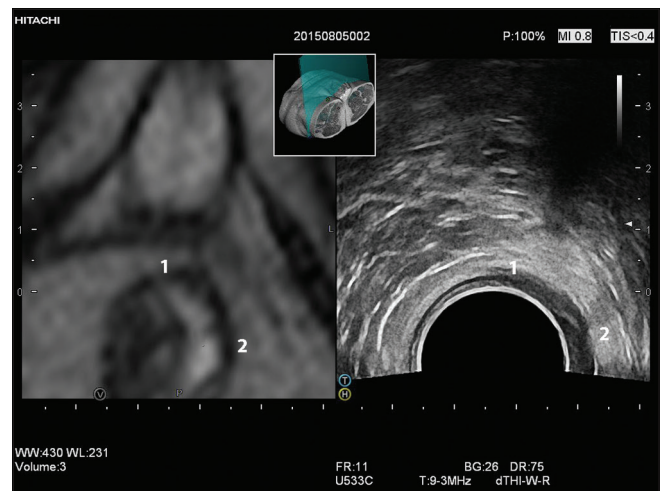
Fusion of magnetic resonance imaging and endorectal ultrasound in a patient with anal fistula. Corresponding points are marked at the 12 and 3 h position (1 and 2, respectively)
